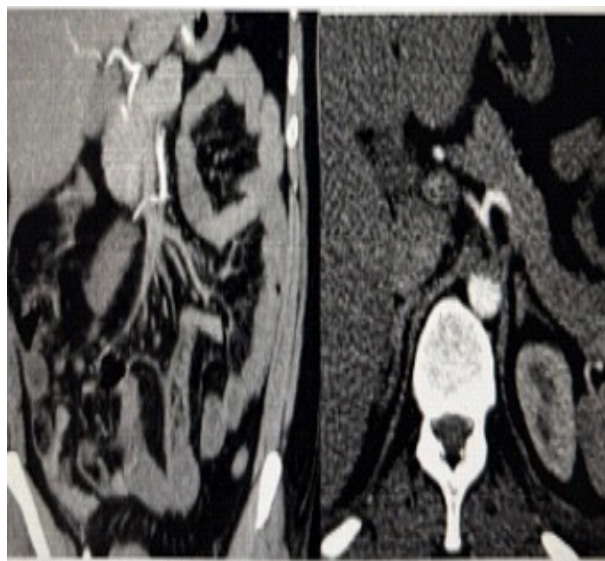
Contrast-enhanced computed tomography of the abdomen showing complete occlusion of the superior mesenteric artery (arrow), associated small bowel ischemia, and splenic infarction.
